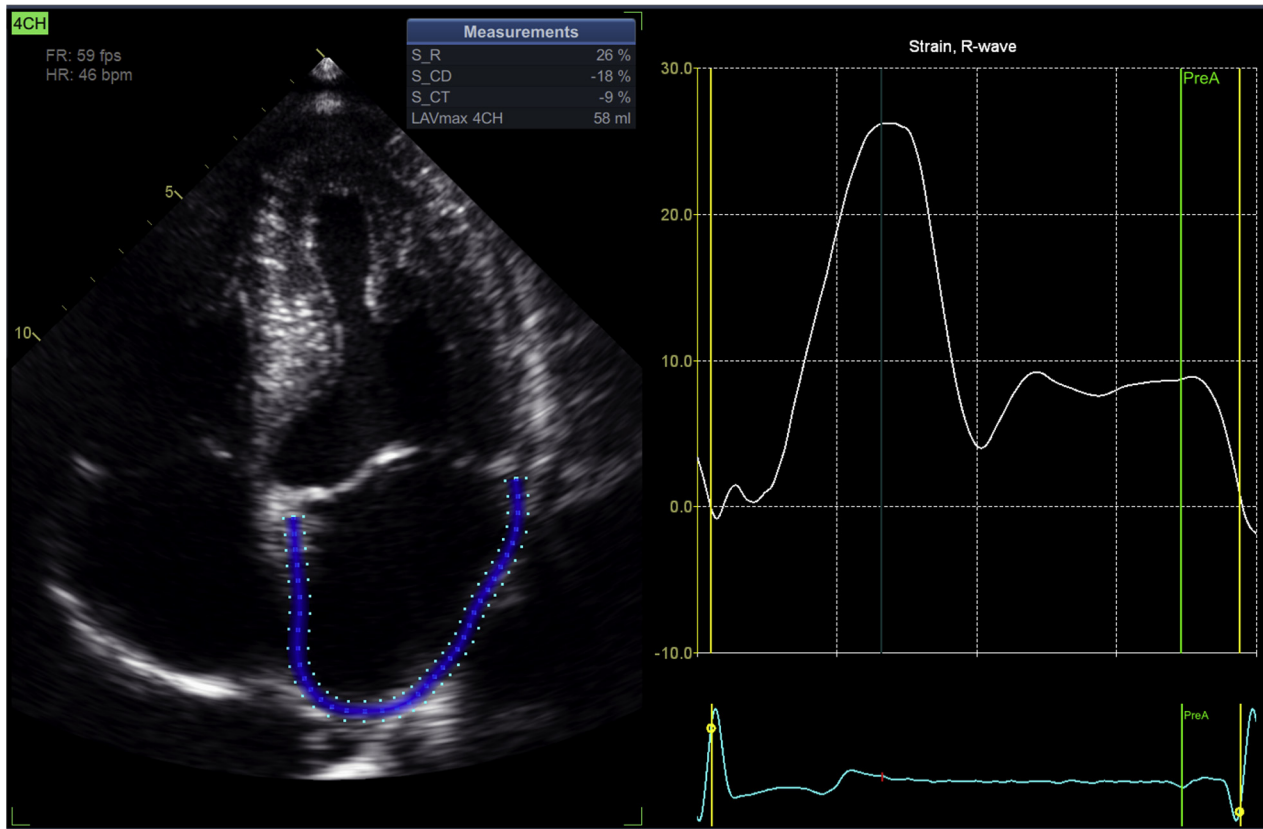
Dedicated software package to measure LA longitudinal strain using automated tracing of the LA endocardium in the apical four-chamber view and following the recommendations of the EACVI/ASE/Industry Task Force for strain standardization.⁶⁵ This software package measures LA longitudinal strain using the four-chamber apical view and R wave as the only time reference. In addition, the software package provides single-plane LA maximal volume (LAV_{max}). S_CD, LA longitudinal strain conduit; S_CT, LA longitudinal strain contraction; S_R, LA longitudinal strain reservoir.
